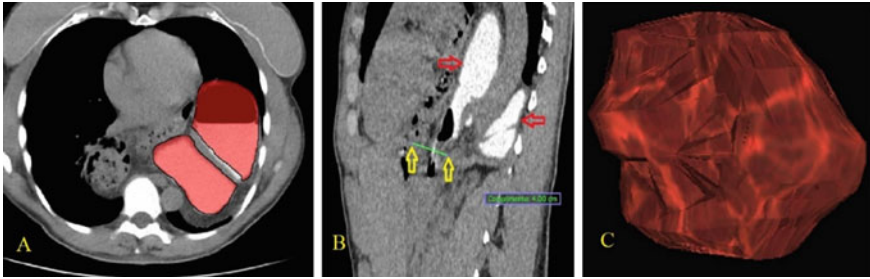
A Axial CT section showing the entire stomach (red) in an intrathoracic position. B CT sagittal section showing the entire stomach (red arrows) above the diaphragm, with a large hiatal defect, with an anteroposterior diameter of 4 cm. C 3D image reconstruction, showing 100% of the herniated volume, associated with gastric volvulus
